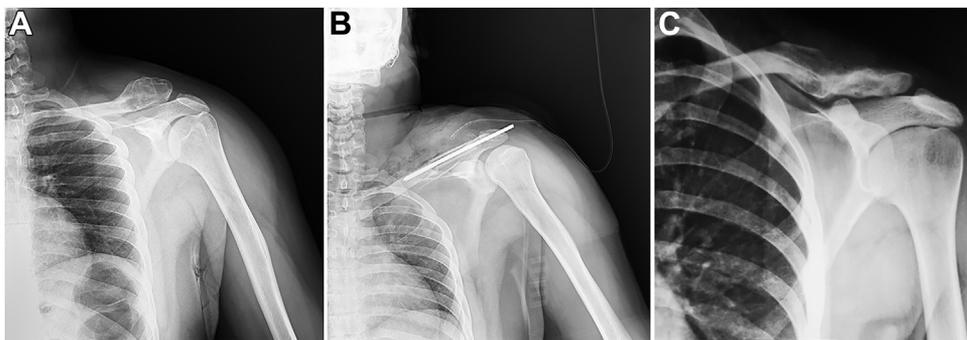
Anteroposterior radiographs of the shoulder of a 24-year-old man with an aneurysmal bone cyst of the lateral end of the clavicle (case 10). (A) Before surgery. (B) Immediately after segmental resection and bone reconstruction with fibular allograft. (C) Three years after surgery.
